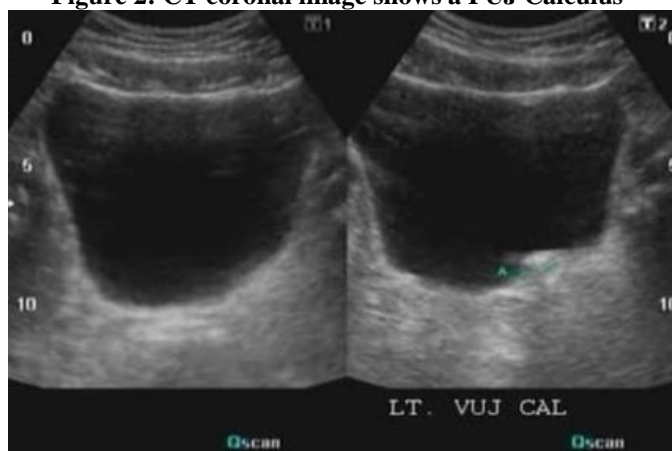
Ultrasound image of calculus at left VUJ
